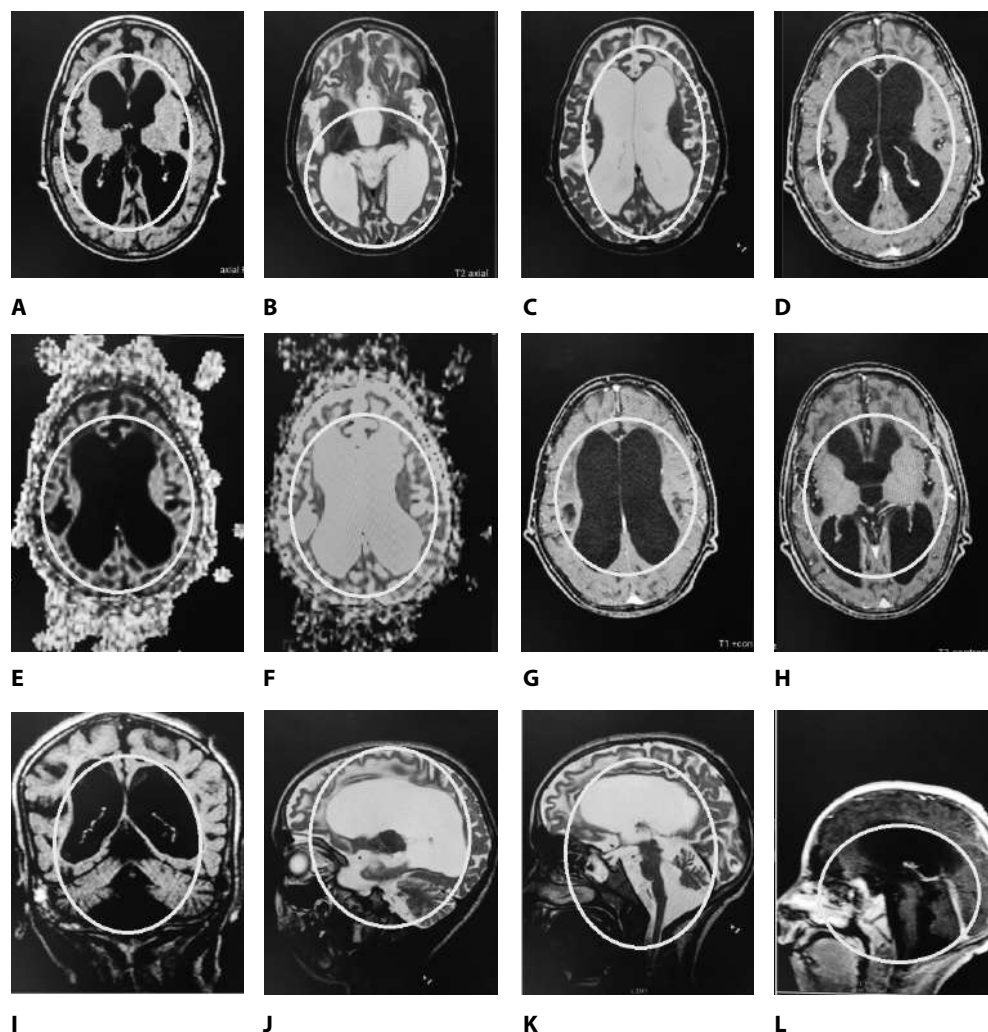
7-years-old girl, this is agenesis of the corpus callosum: A. FLAIR axial: hydrocephalus racing car sign (CSF fluid signal drop). B. T2WI axial: hydrocephalous racing car sign (CSF fluid SI). C. T2WI axial: dilated lateral ventricles. D. T1 axial + contrast: normal parenchymal enhancement (no enhancing lesion). E. DWI: free diffusion. F. ADC map: free diffusion. G. T1 axial + contrast: normal enhancing parenchyma (no mass). H. T1 axial + contrast: normal enhancing parenchyma (no mass). I. T1 coronal + contrast: normal enhancing brain parenchyma (no enhancing mass)
